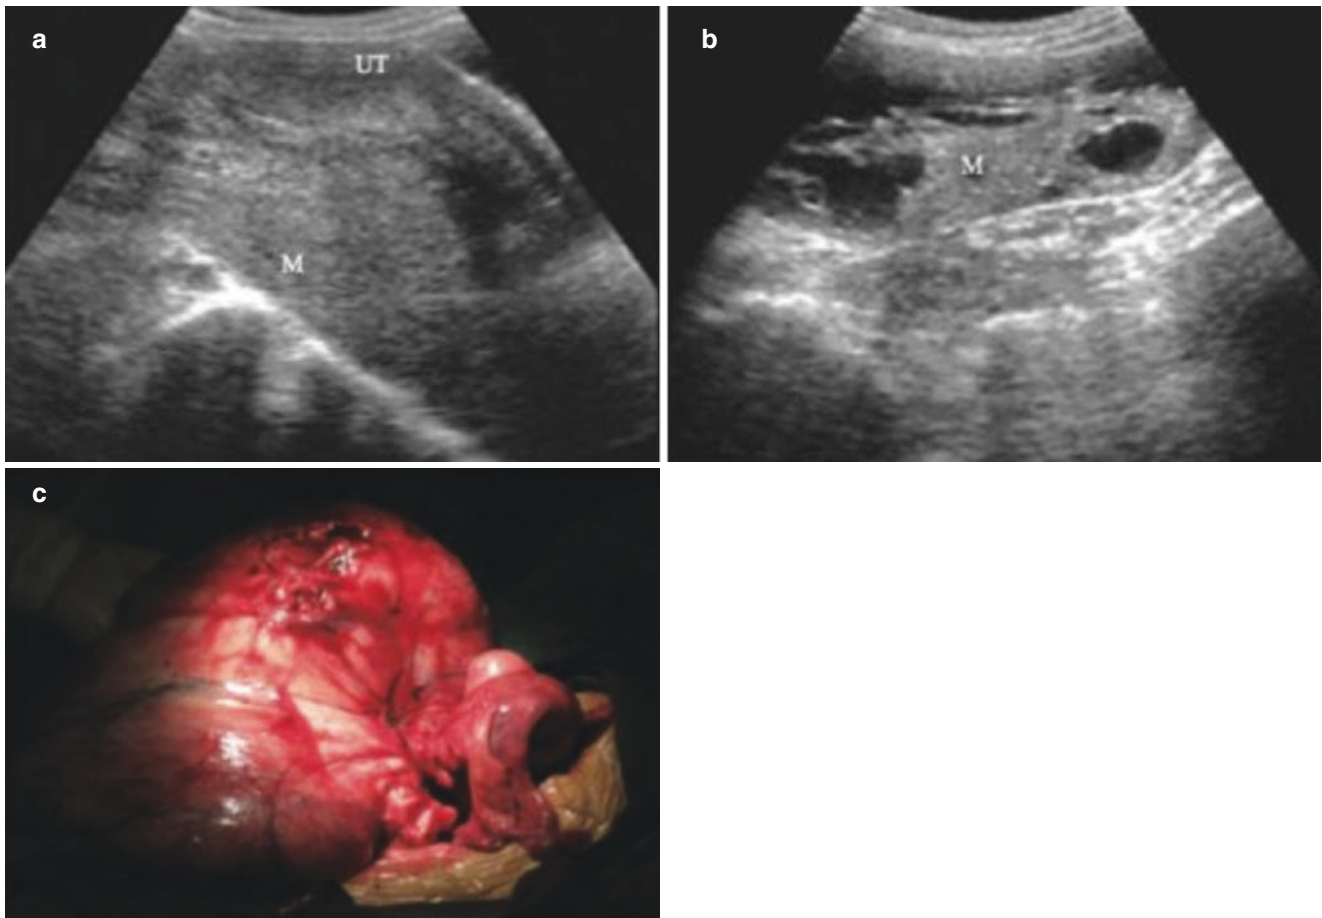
A 41-year-old patient presents with a palpable mass in the abdomen, with normal menstruation. (a, b) The ultrasonography shows a normal-appearing uterus and a mixed mass at the right posterior to the uterus with solid and cystic heterogeneous. As there are irregular fluid
